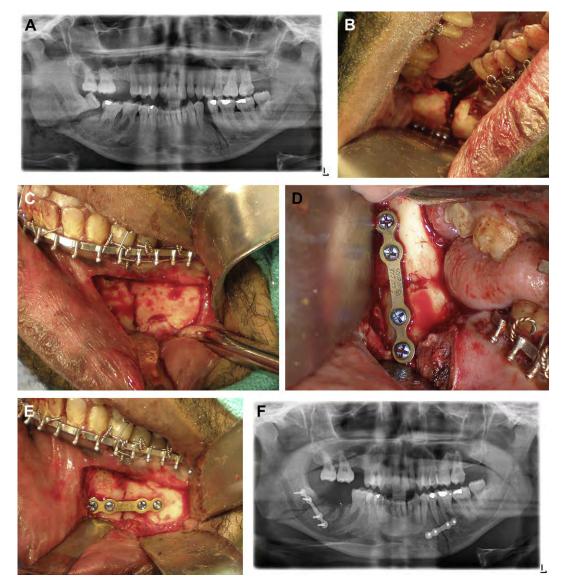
(A) Preoperative panoramic radiograph of right angle, left body of mandible fractures. (B) Intraoperative photo of right angle fracture after extraction of tooth #32 in line of fracture. (C) Intraoperative photo of the left body of mandible fracture with the mental nerve isolated. (D) Intraoperative photo of 2-mm LMP after satisfactory reduction of the right angle fracture. (E) Intraoperative view of 2-mm LMP and four 8-mm by 2-mm monocortical locking screws placed superior to the low-exiting mental nerve to stabilize the reduced left body fracture. (F) Postoperative panoramic radiograph confirms 2-mm. LMP and screws placement at the left body fracture, inferior to the short bicuspid and first molar roots and superior to the low riding inferior alveolar canal.
